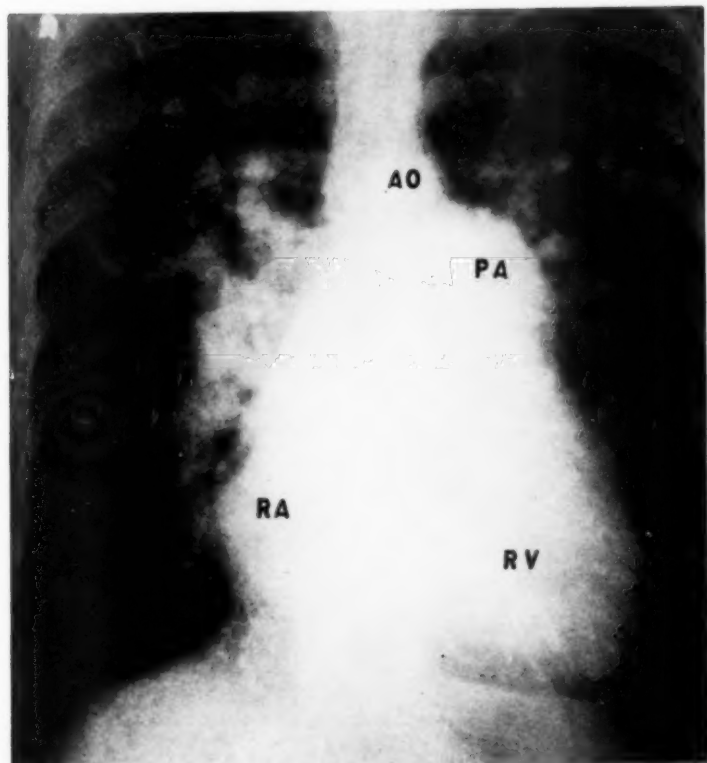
Interatrial Septal Defect.* Male, 42. Diminished cardiac reserve, 12 years. Loud systolic murmur along left sternal border and "bilar dance" on roentgenoscopy. Frontal angiogram at eight seconds. Note opacification of small aorta (AO), reopacification of right atrium (RA), right ventricle (RV) and tremendously dilated pulmonary artery and branches. Diagnosis confirmed by cardiac catheterization (superior vena caval blood: 7.6 vol. per cent oxygen, right atrial blood 15.4 vol. per cent oxygen).
